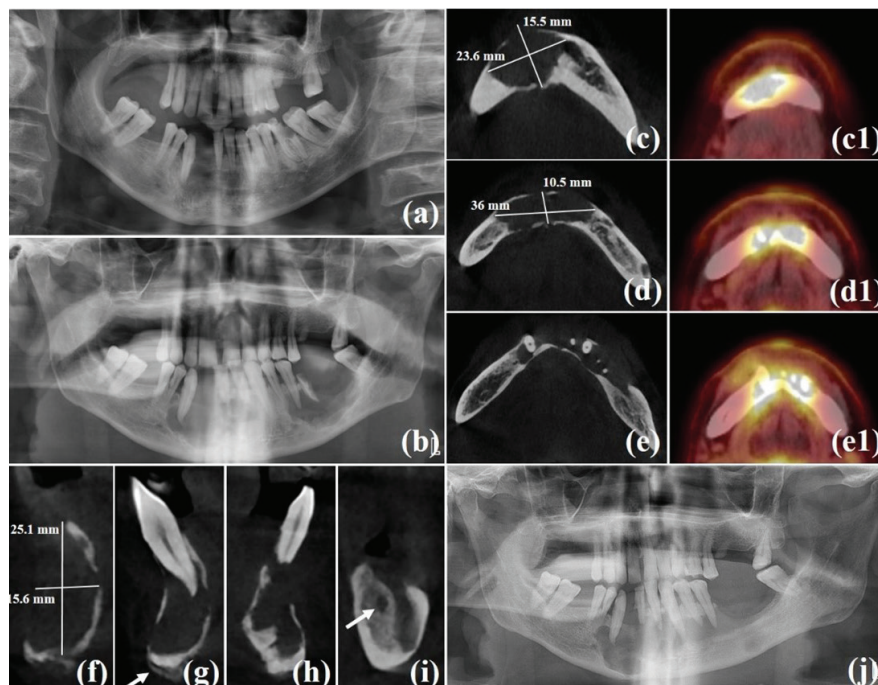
Radiographic presentation of Case 2. (a) Panoramic radiography image of the patient from one year ago. (b) Panoramic radiography taken at our hospital showing scooped-out-shaped and ill-defined alveolar bone destruction in the mandibular anterior and left posterior regions, and diffuse bone loss in the right maxillary posterior region. (c-e) Axial CBCT sections revealing the extensive bone destruction in mandible. (c1-e1) PET scan disclosing the hypermetabolic activity in the anterior and left posterior regions of the mandible. Sagittal CBCT sections of the mandible presenting (f) perforation of buccal and lingual cortical bones, (g) periosteal new bone formation in the anterior region (arrow), (h) external root resorption in tooth #31, and (i) lingual displacement of the inferior alveolar canal (arrow). (j) Panoramic radiography revealing spontaneous regression after the incisional biopsy in the left mandibular posterior region.
